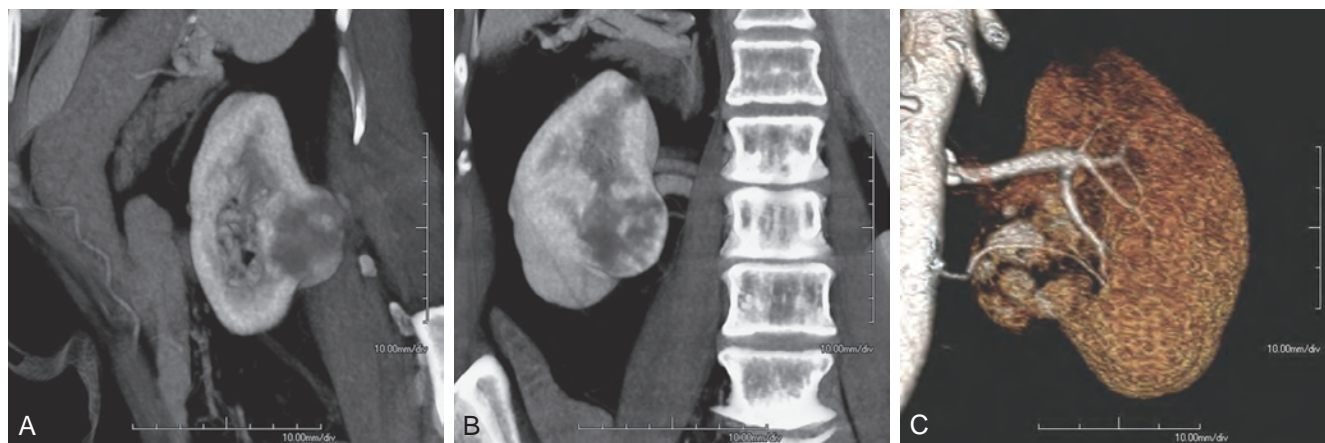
A, Contrast-enhanced computed tomography scan demonstrating right renal mass. B, Three-dimensional reconstruction demonstrates a large intrarenal component to the mass. C, Arterial reconstruction shows lower pole renal artery in close proximity to the renal mass.
